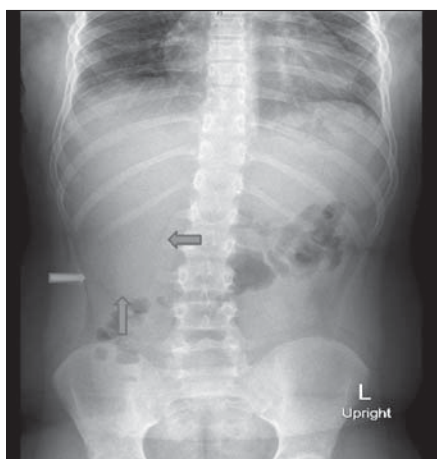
Plain X-ray abdomen showing radiolucent line in right hypochondrium (arrows)
